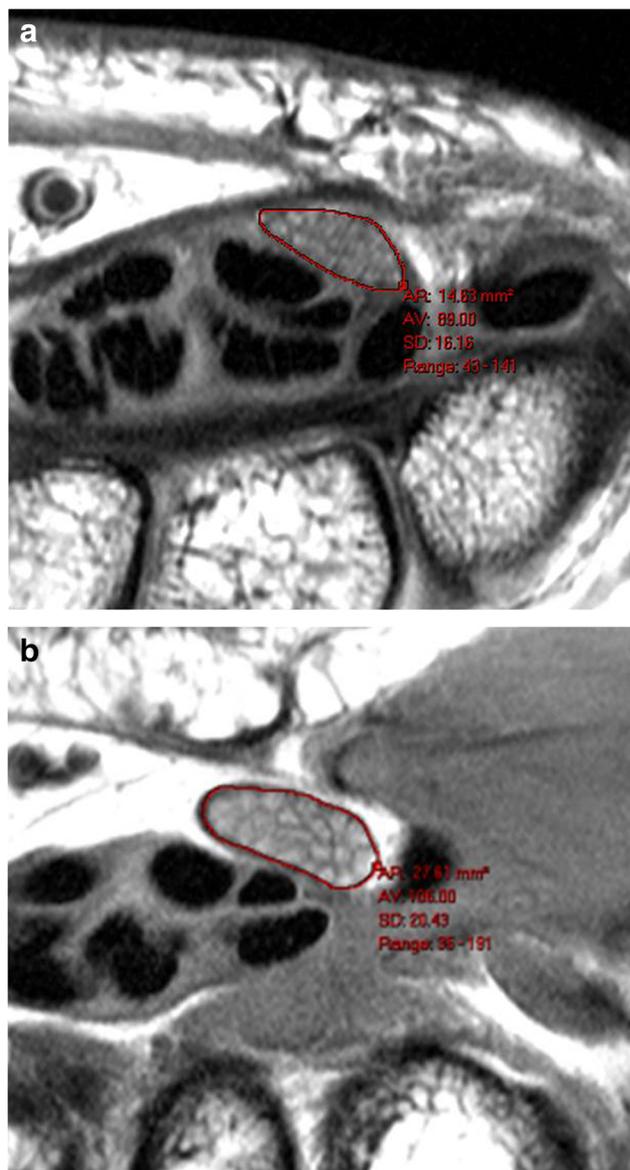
a Proton density axial MR image of another 50-year-old woman with CTS proximal to the carpal tunnel. The median nerve CSA outlined by the *solid line* is mildly enlarged (14.63 mm²) but less than 15 mm² (the designated optimal cut-off value). b Proton density axial MR image of the same patient distal to the carpal tunnel. Median nerve CSA outlined by the *solid line* is markedly increased (27.61 mm²)
